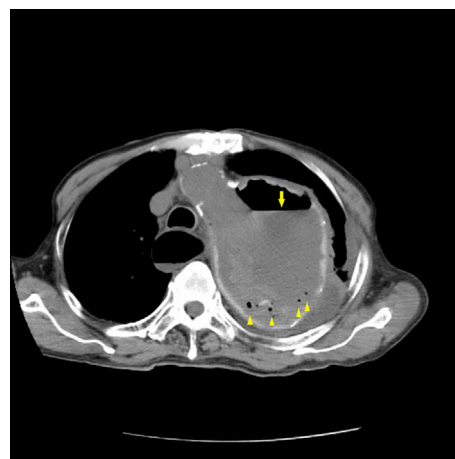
Chest CT showing a perigraft abscess with air bubbles (arrowheads) and fluid collection (arrow) in the thoracic aorta.
